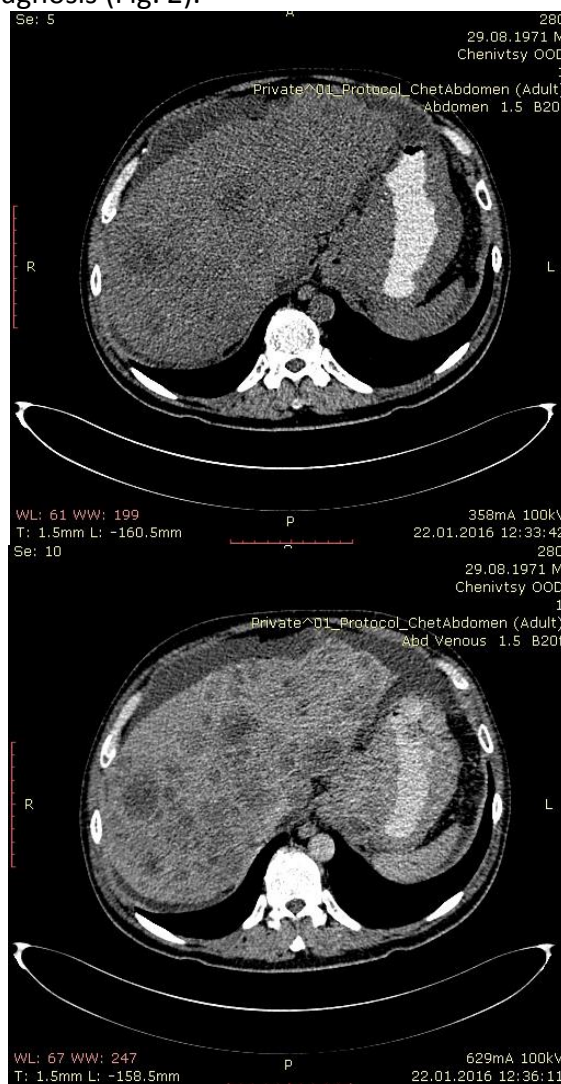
CT scan of the patient O. with cancer of cardia of stomach with metastases to the liver and retroperitoneal lymph nodes.
